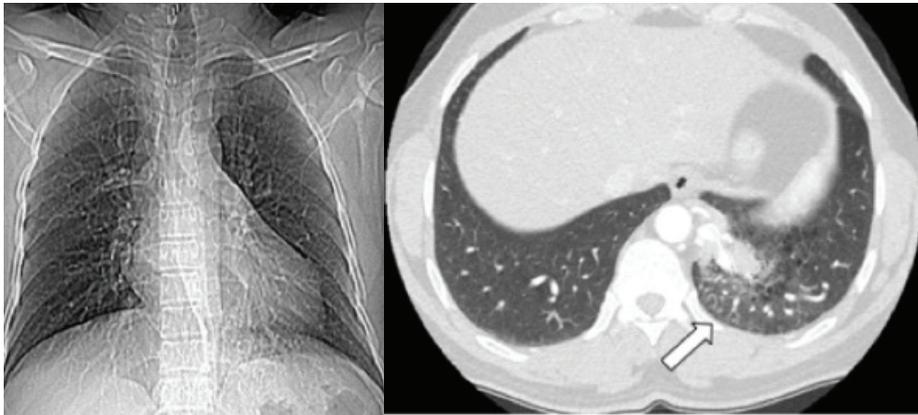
A-Chest radiograph of patient with pulmonary sequestration B-Thoracic computed tomography demonstrated pulmonary sequestration with increased parenchymal consolidation at the left lower pulmonary area (arrowhead).
